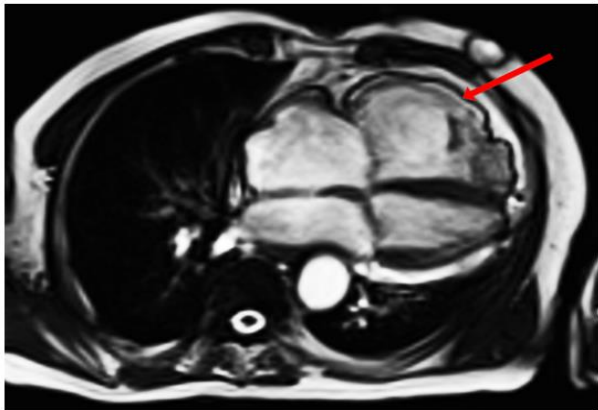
Delayed contrast-enhanced MRI show delayed enhancement (arrows) confirming presence of fibrosis. Note right ventricular enlargement. True fast imaging with steady-state precession cine reveals localized dyskinesia (apex and Pulmonary infundibulum) with akinesia of the inferior wall with markedly diminished ejection fraction.
